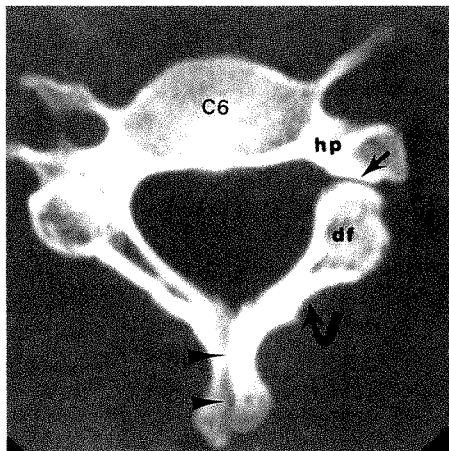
Left C6 spondylolysis in a 34-year-old man injured in a motor vehicle accident. CT scan shows smoothly margined cleft (*straight arrow*), posteriorly positioned dorsal fragment (*df*), hypoplastic ipsilateral pedicle (*hp*), and spina bifida occulta (*arrowheads*). Dysplastic ipsilateral lamina is also seen (*curved arrow*). These findings are diagnostic.
